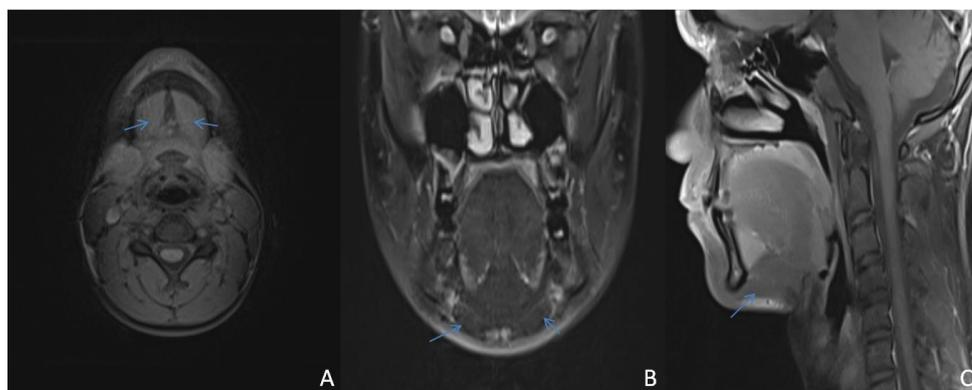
Multiplanar MRI evaluation of the digastric muscle: (A) Axial image demonstrating anterior digastric bellies (arrows), (B) Coronal image confirming bilateral symmetry and morphology (arrows), (C) Sagittal image showing normal anterior belly course and insertion (arrow).
